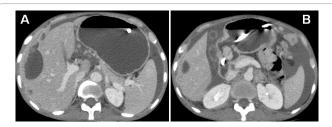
(A) Axial CT enteroclysis image showing enhancing soft tissue deposit along peritoneal surface (with associated scalloping of liver margin), omental surface and ascites (B) Omental surface showing nodular enhancing deposits with polyp noted in pylorus of stomach.
